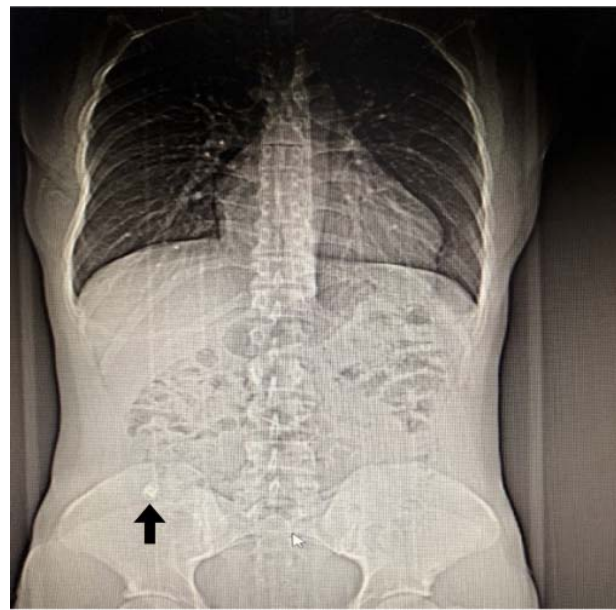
X-ray of the abdominal organs with fistula contrast with an iodine-containing radiopaque agent
